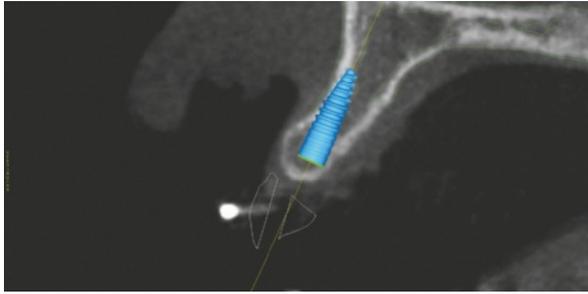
CBCT showing horizontal bone deficiency. Here a narrow ridge still allows placement of a reduced-diameter implant. Use of a regular-diameter implant may require additional grafting procedures.
